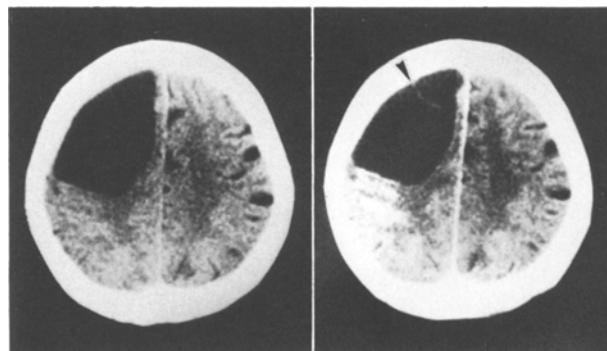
Plain CT (left) and contrast CT (right) showing a large cystic lesion in the left frontal lobe. In contrast CT, linear shadow (arrow) in the cyst probably corresponds to veins in the cyst wall
